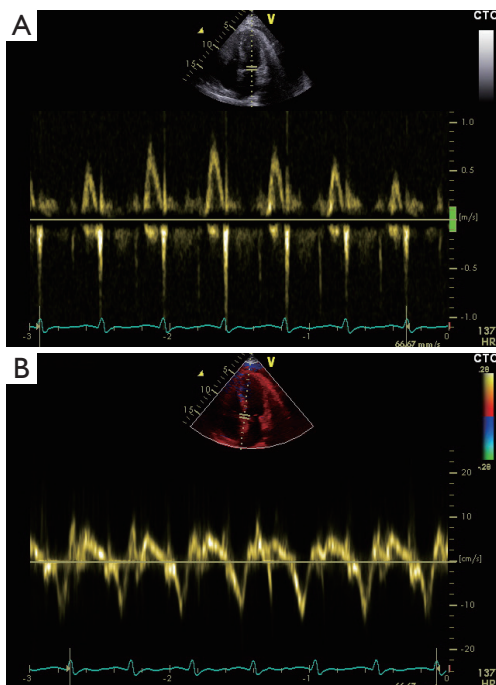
The Doppler velocity wave of the patient before surgery.
